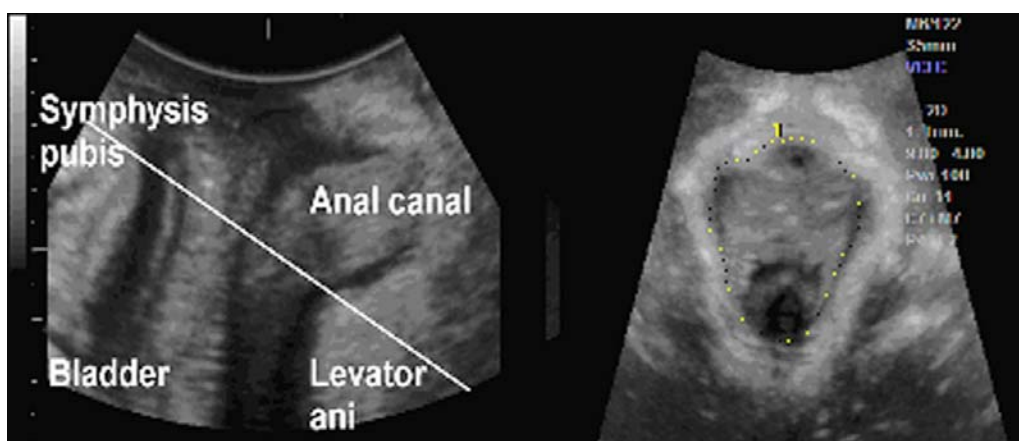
Identification of the hiatal plane on 4D ultrasound imaging: midsagittal plane on the left, oblique axial on the right. The small dots on the right image shows measurement of the hiatal area.
